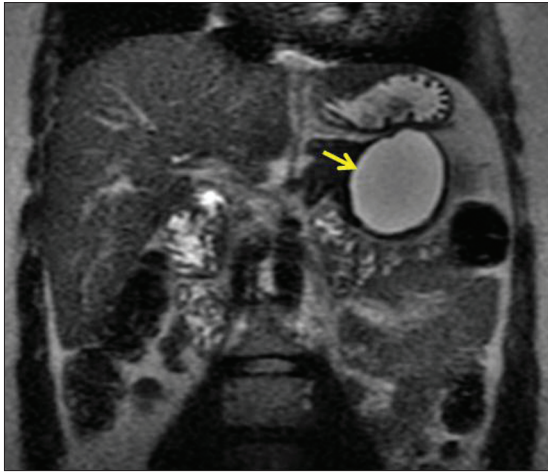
A 51-year-old female with MCN. T2-weighted MRI shows typical location and paucilocular appearance (arrow). No malignancy on surgical pathology
